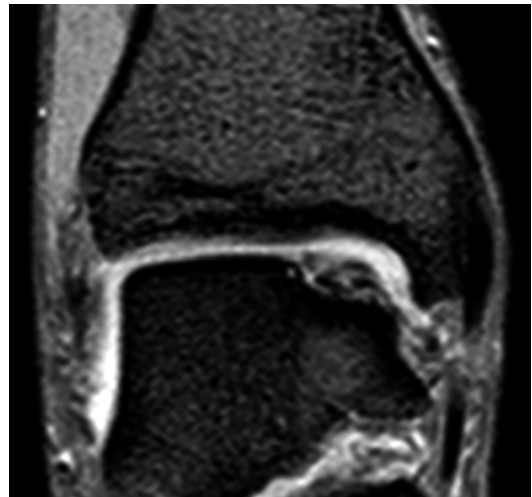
Coronal view of MRI scan performed for chronic medial OCL. MRI is the best diagnostic tool, as it can visualize the cartilage and the subchondral bone, as well as other soft tissues as ligaments
